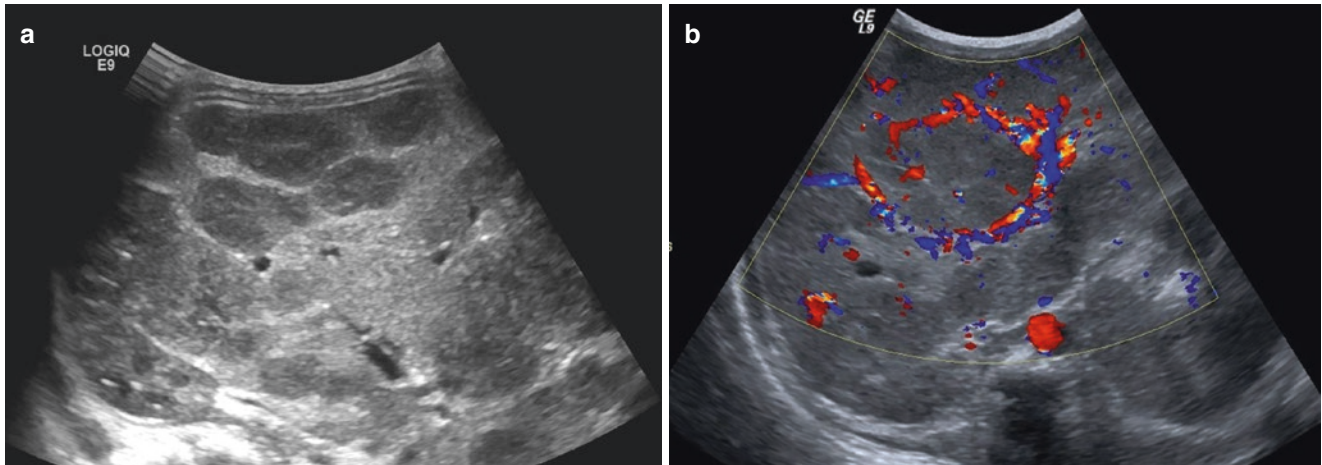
Infantile Hemangioma: (a) mass in the liver which is hypervascular on Doppler US (b) reveal multiple hypo-echoic liver lesion which are suggestive of infantile Hemangioma
